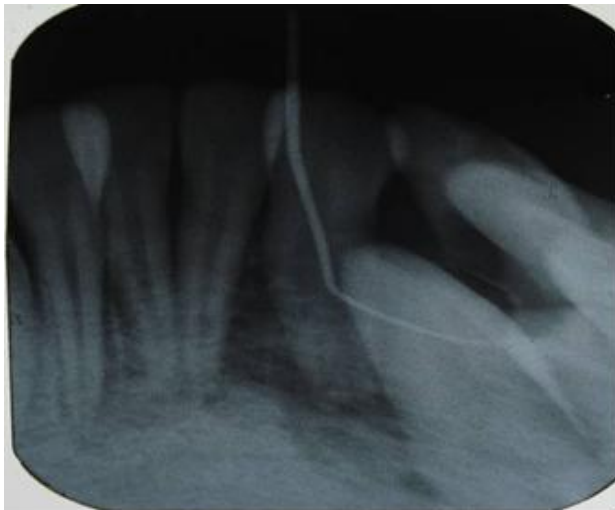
Radiographic view of the sinus.
